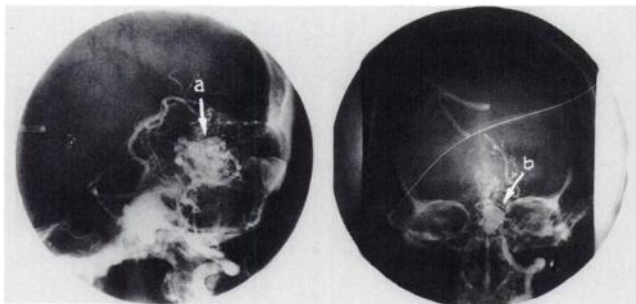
Cerebral arteriogram confirming the AVM (a) and basilar artery aneurysm (b) identified by MR imaging.
